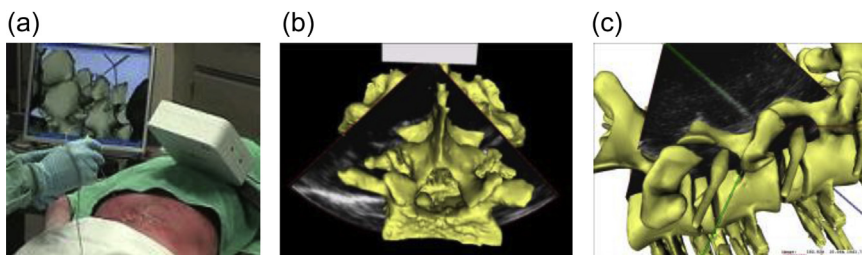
(a) Feasibility study of the needle guidance in cadaveric study, (b) augmented virtuality view of the spine anatomy with ultrasound overlay, and (c) enhancement of needle visualization in which the needle is highlighted in green.
